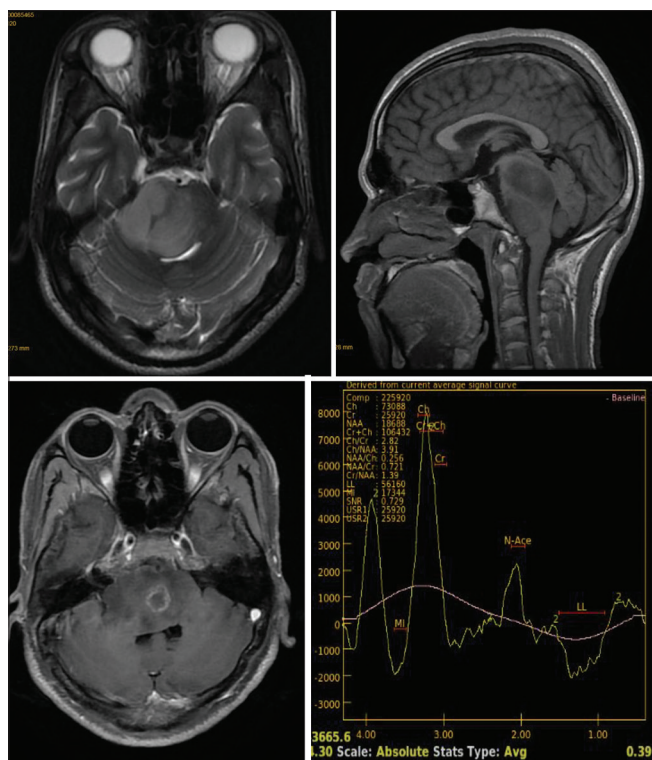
Axial T2, sagittal and axial T1 fat saturated pre and post contrast MR images showing a large T1 & T2 hypointense, heterogeneously enhancing lesion involving and expanding the brainstem. MRS shows choline peak, which is suggestive of brainstem glioma
